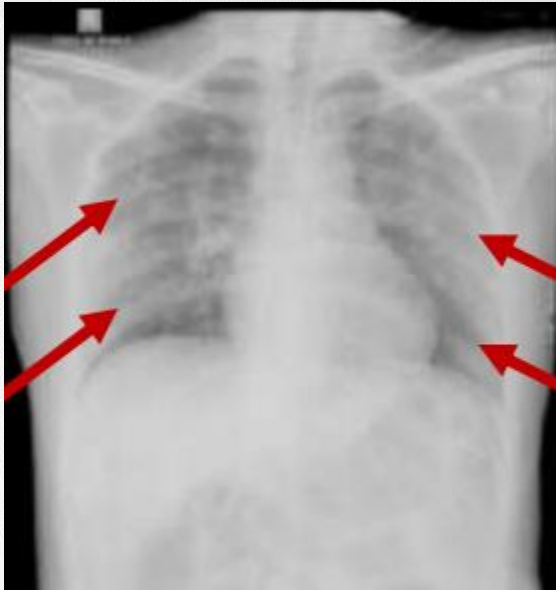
Case 1. Chest radiograph on admission, apico-posterior view showing bilateral hazy densities in the mid- and lower lung fields (arrows).
